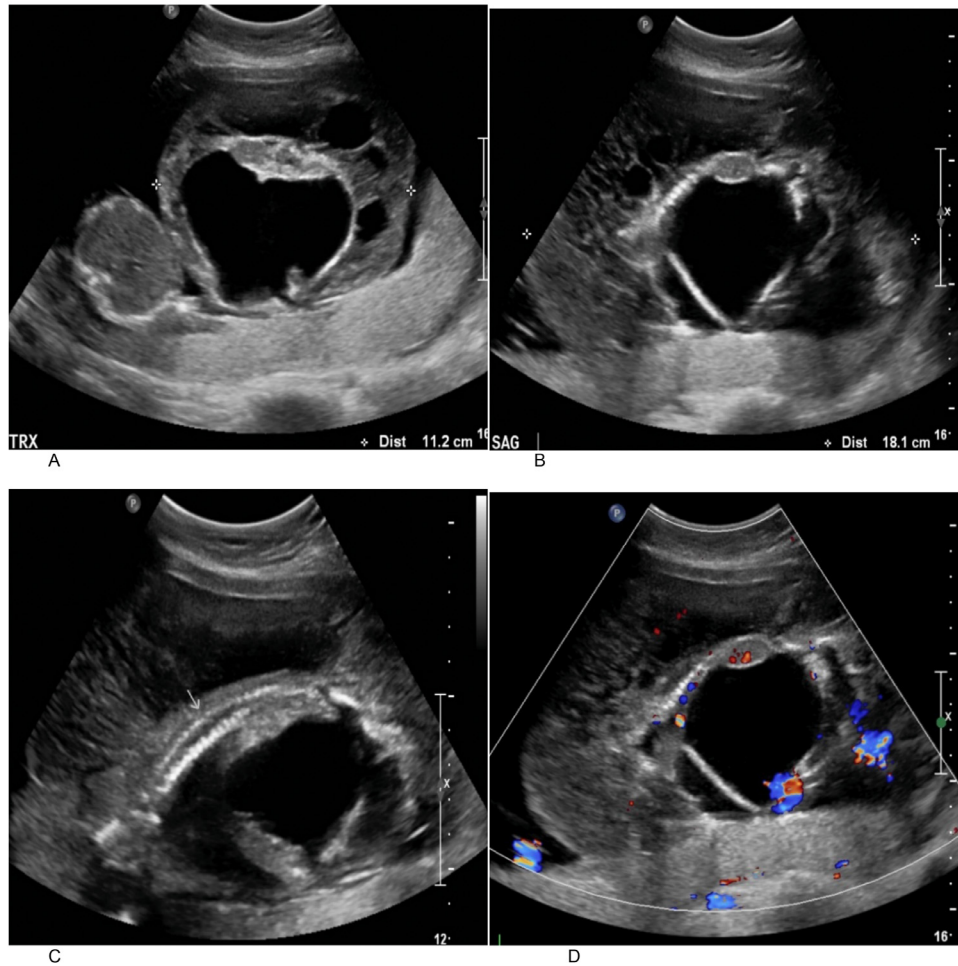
(A) Transverse section of Twin B. Twin A is to the left of the image. Also note the posterior lying placenta (B) Sagittal section of Twin B. Note the fluid-filled abdomen and thoracic cavity. . . Sagittal spine is partially visible in this view. (C) Twin B in grayscale imaging. Note the sagittal spine with lumbar & thoracic vertebra relatively well seen in this plane of section. (D) Colour doppler on twin B.
